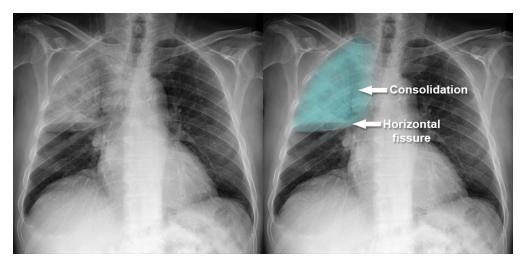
Lobar pneumonia chest X-ray showing consolidation
